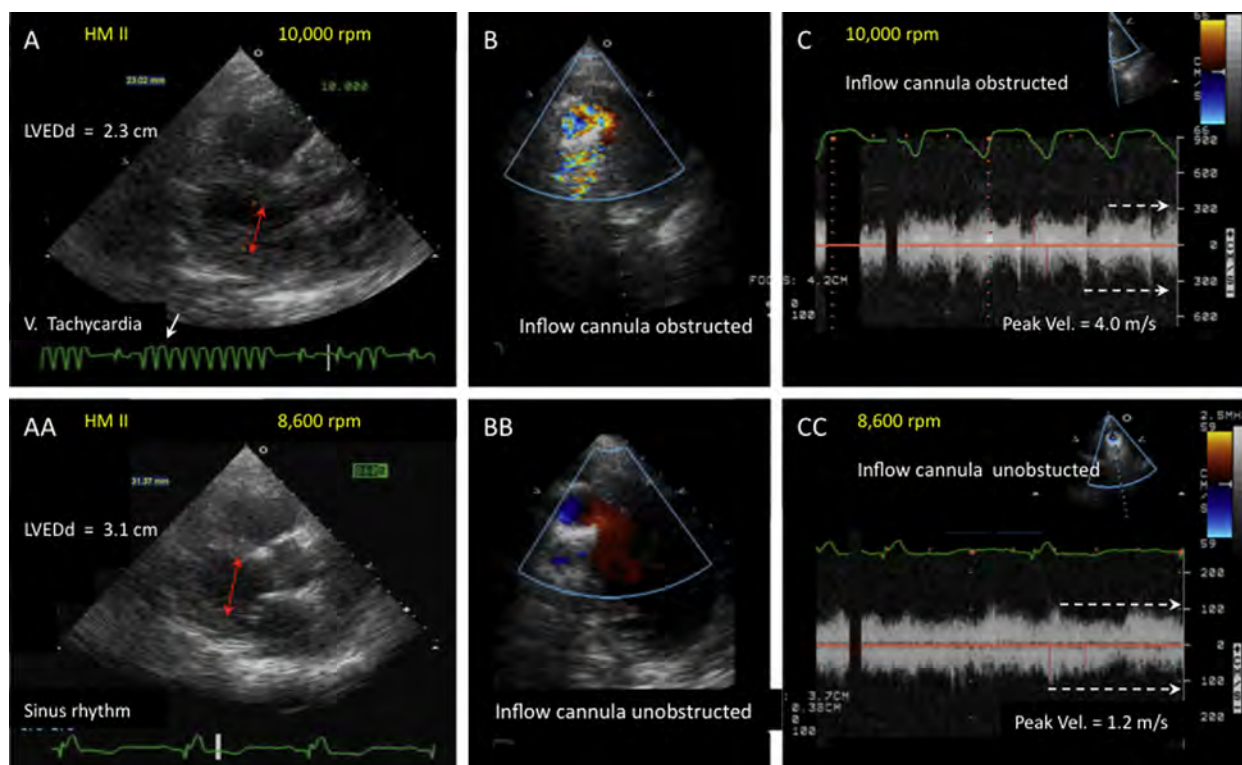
Mechanical ventricular tachycardia due to a suction event at a high pump speed (10,000 rpm), due to new hypovolemia resulting from a gastrointestinal illness. (A) Small LV chamber size (LVEDd = 2.3 cm, red arrows), with frequent nonsustained ventricular tachycardia (white arrows). See also [Video 39](#). (B) Turbulent, aliased inflow-cannula inflow, as assessed by color Doppler. See also [Video 40](#) and [41](#). (C) Complex, "spiky," high inflow-cannula inflow velocities up to 4 m/s on continuous-wave Doppler examination. (AA) Reducing the pump speed (to 8600 rpm) immediately increased the LVEDd (to 3.1 cm, red arrows) and eliminated the ventricular tachycardia (ie, reduced mechanical contact between the ventricular septum and the inflow cannula). Normal low-velocity inflow-cannula flow is observed on color-flow Doppler (BB) and continuous-wave Doppler (see also [Video 42](#)) (CC) at the reduced pump speed. The LV size remained small (3.1 cm) because of the hypovolemia, which later resolved. *Note:* Mechanical ventricular tachycardia may also be associated with excessive inflow-cannula angulation towards the septum or other endocardial surfaces after sternal closure, particularly at increased pump speeds.
